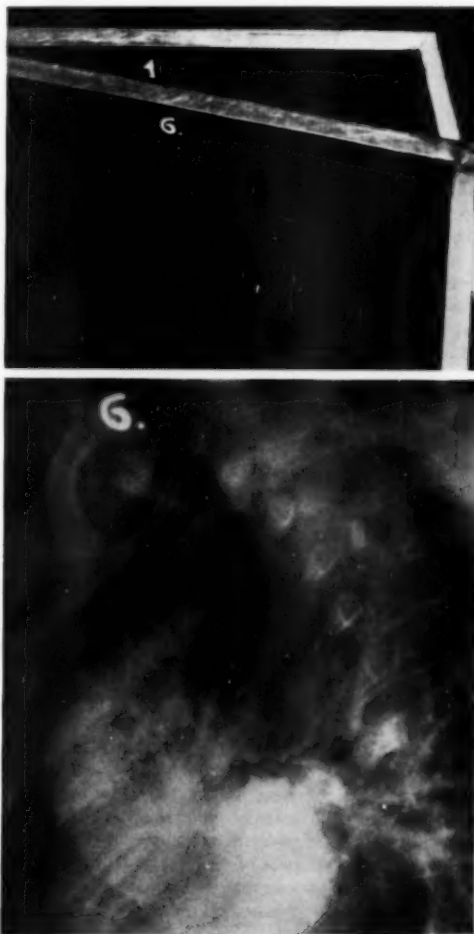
Cassettes showing drilled numbers and resulting roentgenogram.
